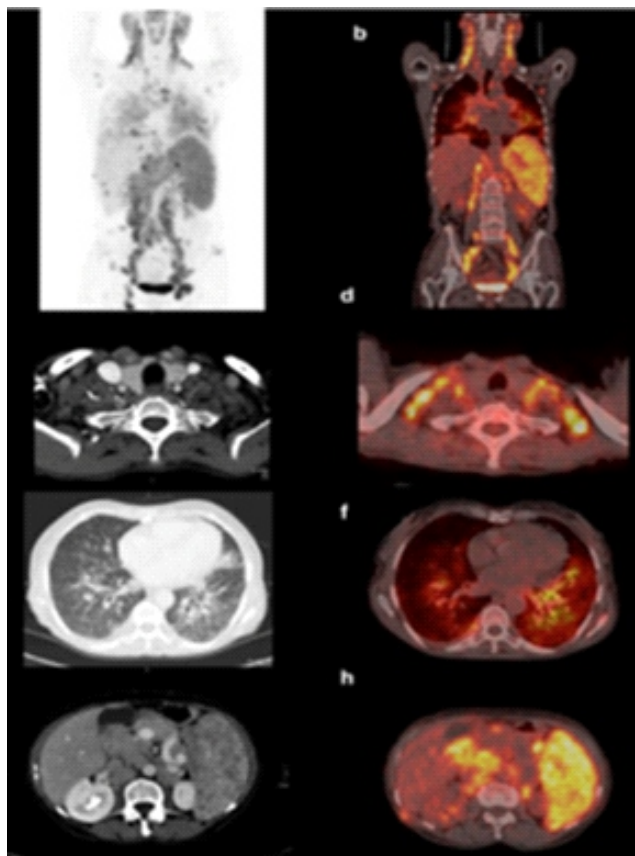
Patient with systemic sarcoidosis diagnosed by biopsy of the laterocervical lymph nodes. Whole body ^{18}F -FDG PET/CT: typical but systemic sarcoidosis with multiple lesions of the supraclavicular and thoracic lymph nodes, lungs, abdominal lymph nodes, liver and spleen [24].
